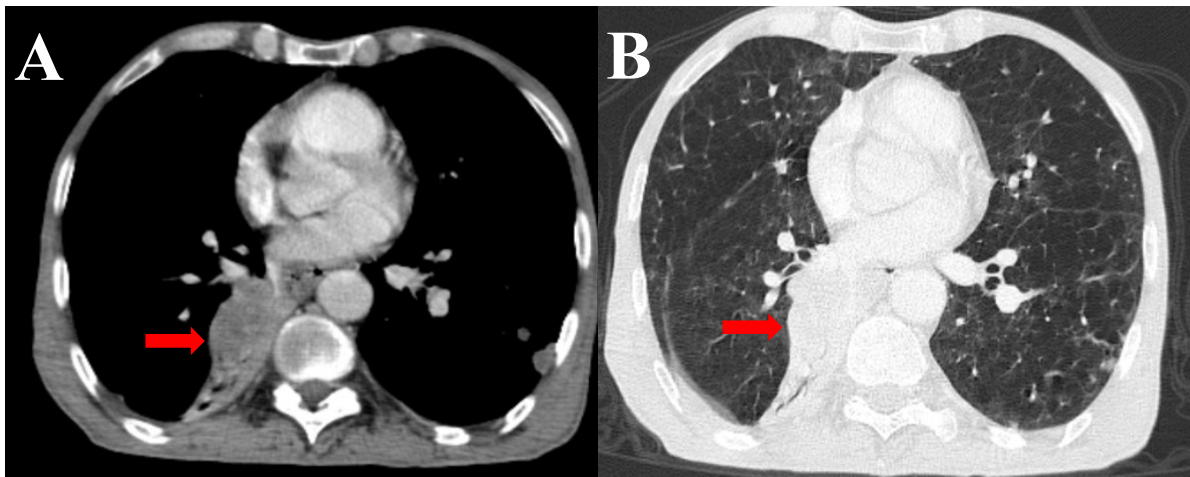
Axial chest CT images in mediastinal window (A) and lung window (B) showing a right mediastinal-pulmonary mass (red arrows).
